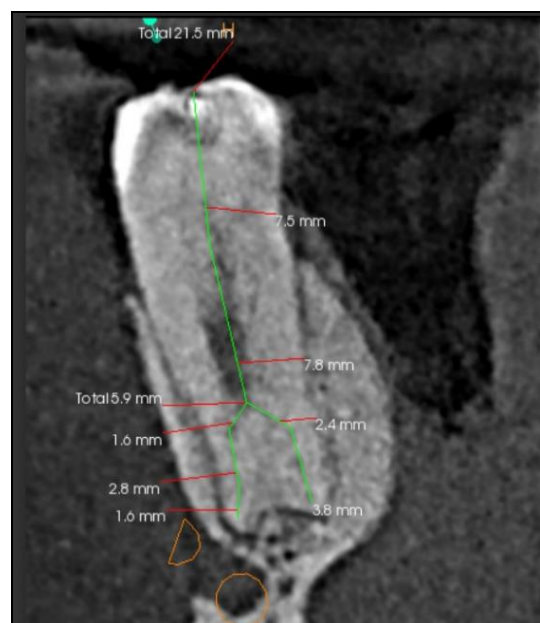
CBCT evaluation of 45
